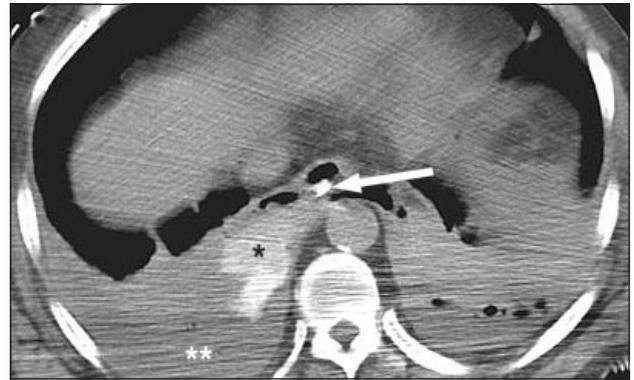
Oesophageal perforation. Axial computed tomography scan shows oral contrast within the right pleural space (asterisk), site of bowel contrast material extravasation (arrow), and right pleural effusion (asterisks).
